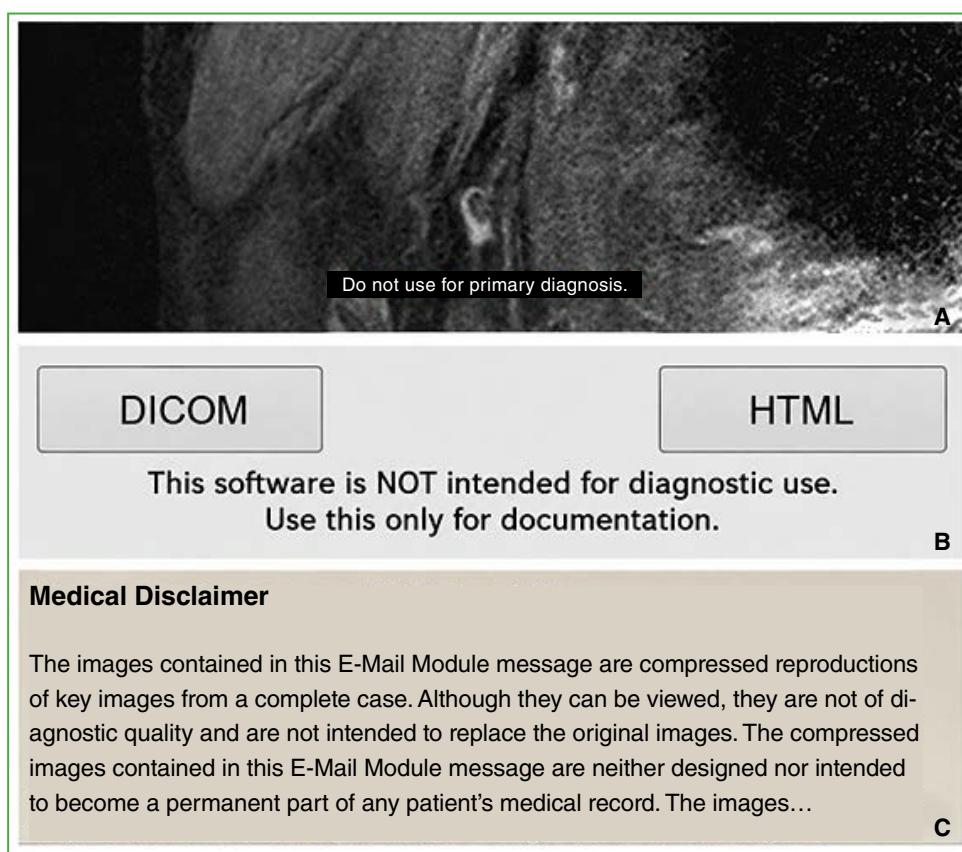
Examples of warning messages accompanying imaging studies requested for diagnostic purposes. A. Magnetic resonance imaging (MRI) study with a warning stating that it “should not be used for primary diagnosis.” B. Another common disclaimer displayed when opening a compact disc containing diagnostic imaging studies states that it should not be used for diagnosis, but only for “documentation.” C. Imaging studies accompanied by a warning stating that the images are not of “diagnostic quality.”
